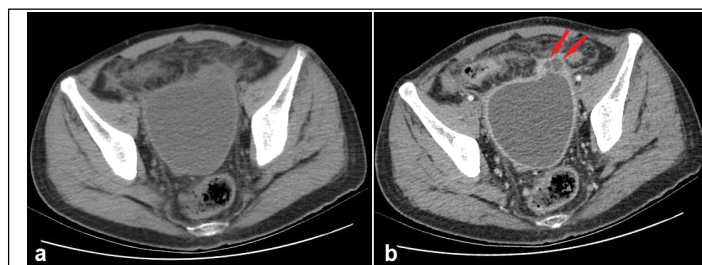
a,b. Axial pre - (a) and post -contrast (b) computed tomography sections through pelvis showing a large hydatid cyst anterior to the rectum. Loculations in the anterior aspect of the cyst is clearly visible only in the post -contrast image (arrows).
